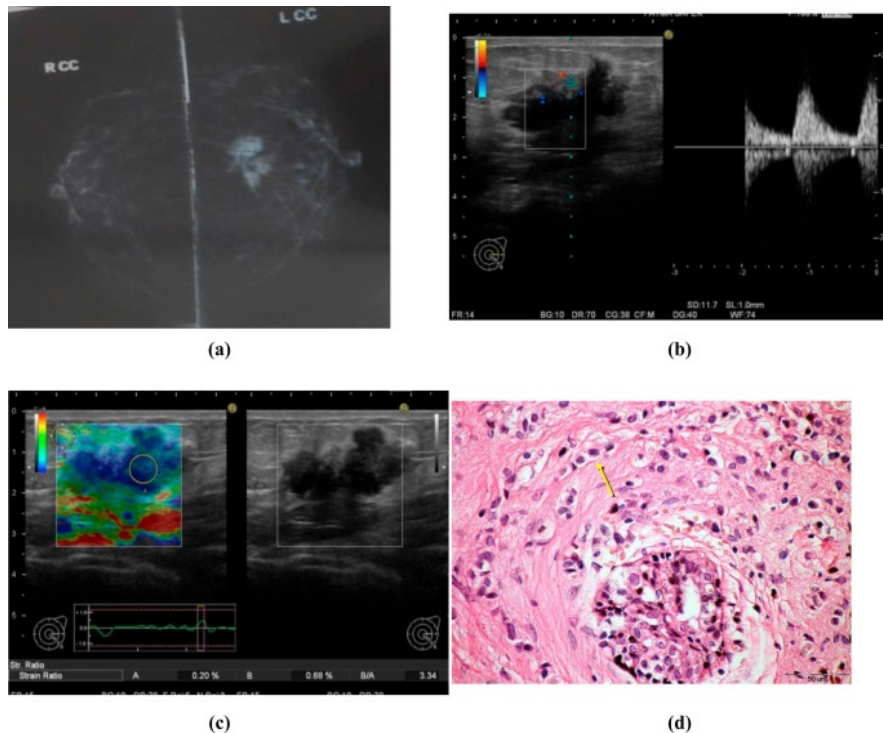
Figure showing 55 years female with palpable left breast lump. (a) Mammogram showed dense opacity with irregular outlines in the inner quadrant from the left breast. (b) Conventional US showed hypoechoic lesion with irregular borders, posterior acoustic shadowing with detected vascularity on color Doppler. (c) elastography of the lesion showed score 4. (d) FNAC of the mass revealed infiltrating ductal carcinoma with small hyperchromatic cells around proliferating ducts.
